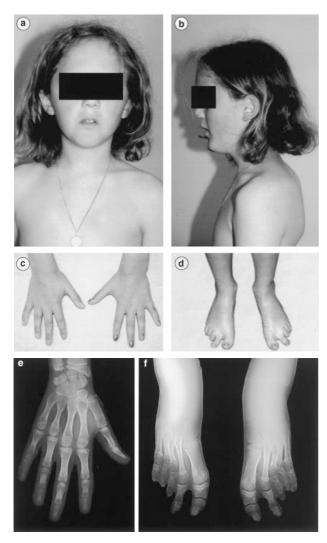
Patient with ADULT syndrome. (a) Note absent nipples, fine hair and small mouth. (b) Note malar hypoplasia. (c) Note bilateral clinodactyly of the Vth finger. (d) Note hypoplastic, over-riding toes, cutaneous 2-3 syndactyly and hypoplastic, discoloured toe nails. (e) X-ray of the left hand at the age of 11 years. Note clinodactyly of the Vth finger. (f) X-ray of the feet at the age of 11 years. Note bilateral hypoplasia of toes III, IV and V.
